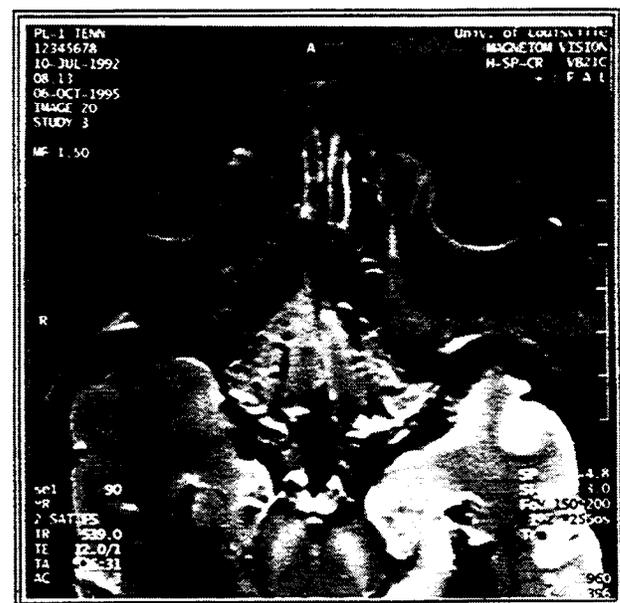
FS MRI of a Head
